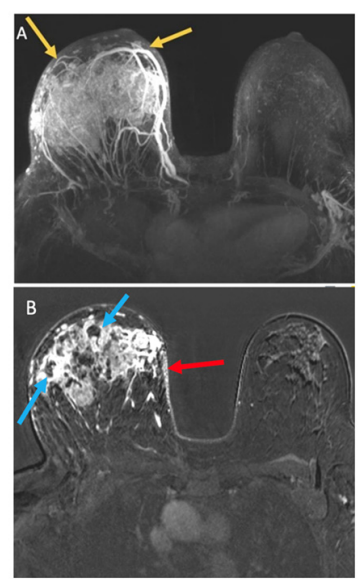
Breast MRI maximum intensity projection (MIP) (a) and axial subtracted contrast-enhanced image (b) demonstrate asymmetric right breast enlargement and enhancement (yellow arrows) with multiple contiguous, irregular, enhancing and partially necrotic masses (blue arrows) throughout the right breast in addition to skin enhancement and thickening (red arrow). The left breast demonstrates no suspicious findings.
